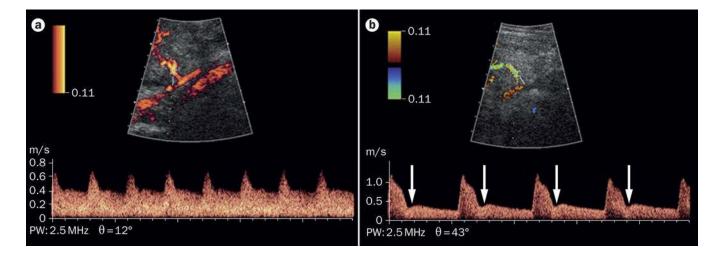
Uterine artery Doppler velocimetry findings in the second trimester of pregnancy A. Normal findings. B. Abnormal findings, indicated by either the presence of bilateral uterine artery early diastolic notches (arrows) or a mean pulsatility index (calculated as [peak systolic velocity – end diastolic velocity]/time averaged velocity, averaged across both uterine arteries), above the 95th percentile for gestational age.
